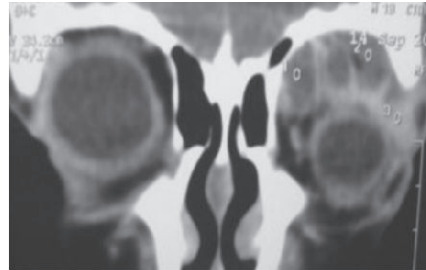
CT scan (coronal view) showing multiple thick walled cavities (abscesses) in the left superior orbit.
